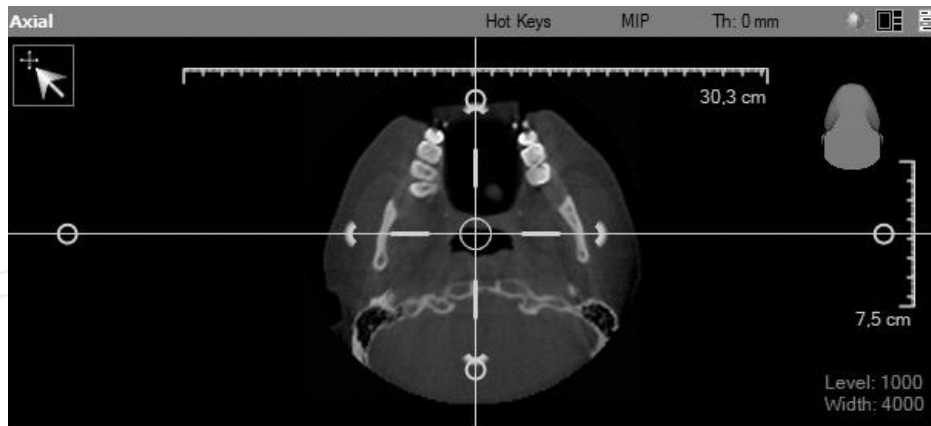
An example of an axial slice of CBCT image
